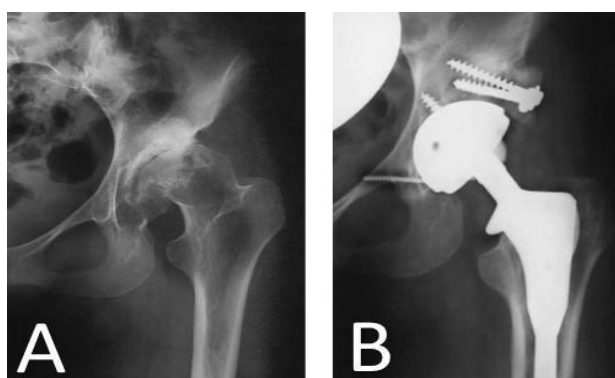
A: Preoperative radiograph of a patient showing neglected hip dislocation. B: Postoperative radiograph taken 10 years after surgery, showing graft union to host bone ⁽⁵²⁾.
